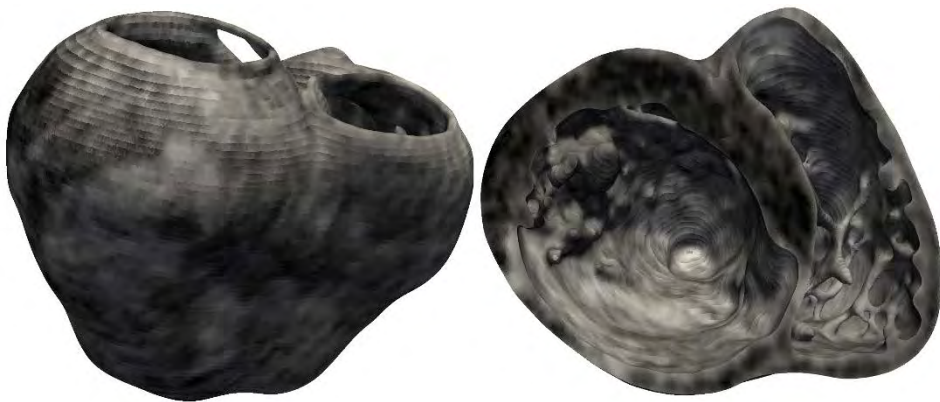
Grey intensity levels of the DE-MRI mapped into the hexahedral volume mesh of the 3D ventricular model, showing a postero-basal view of the whole model (*left*) and a basal view of a cross-section in the short-axis plane (*right*). The latter view shows the thinning (atrophy) of posterior, postero-lateral and postero-septal walls of the LV as a consequence of the healing process of the MI, as well as the concentration of high-intensity levels (closer to white) in those regions due to the accumulation of gadolinium-based contrast agent.
